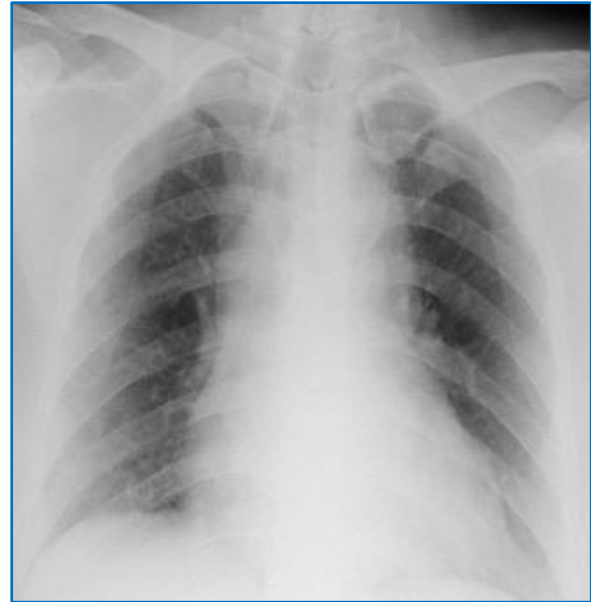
Chest X-ray showing non-homogeneous ground-glass opacities
